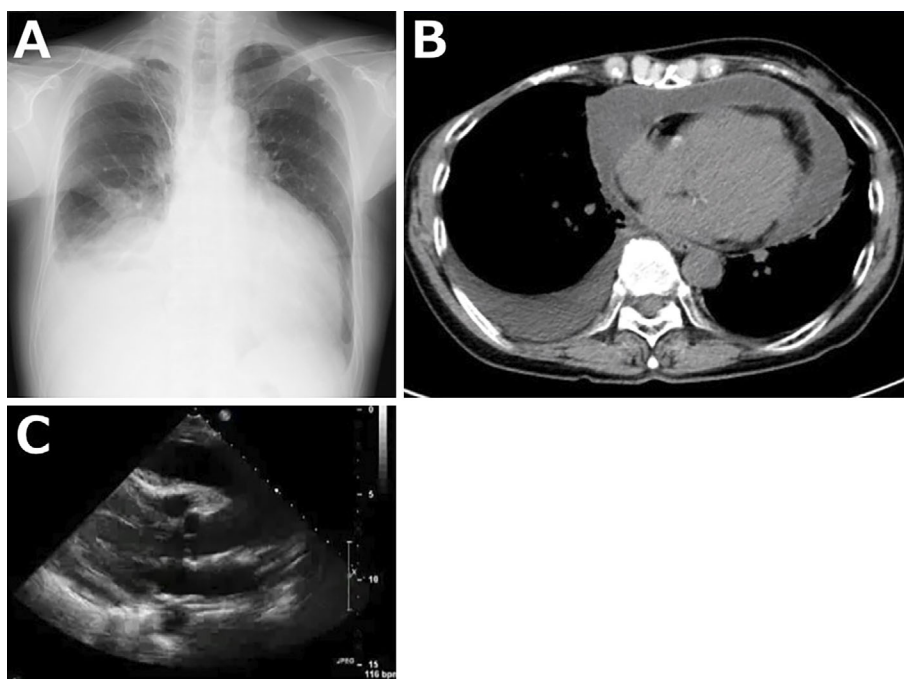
A: Chest radiography shows cardiomegaly with bilateral pleural effusion. B: Chest computed tomography shows a thickened pericardium with massive pericardial effusion and bilateral pleural effusion. C: Transthoracic echocardiography shows pericardial effusion.
